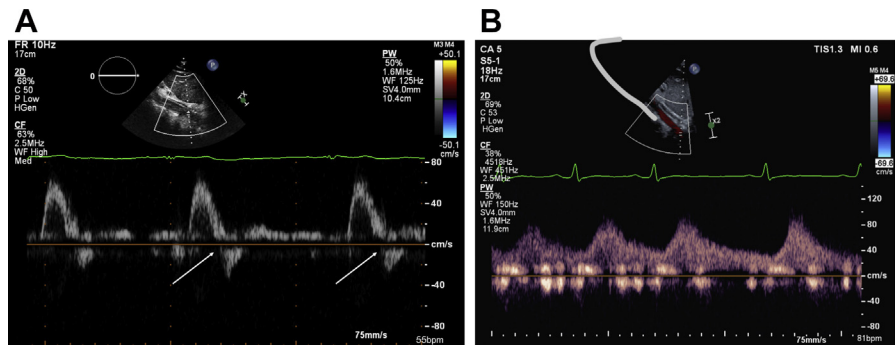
Normal pulsed-waved Doppler interrogation of the abdominal aorta (A) typically demonstrates a brisk upstroke and downstroke followed by early diastolic flow reversal (arrows). In contrast, the abdominal Doppler examination in a 21-year-old man (B) who underwent previous end-to-end anastomosis demonstrates a dampened, low-velocity signal with continuation throughout diastole suggests significant recoarctation.
